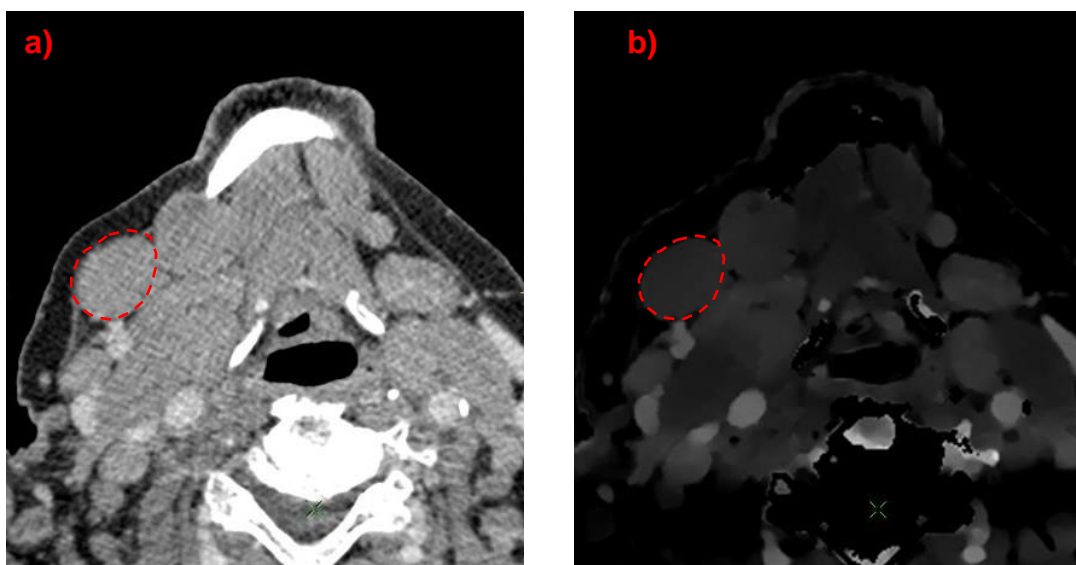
a) CT image in venous portal phase of pathological lymph node submandibular to the right in Hounsfield scale, primary diagnosis of a lymphoma b) Corresponding iodine concentration map.
